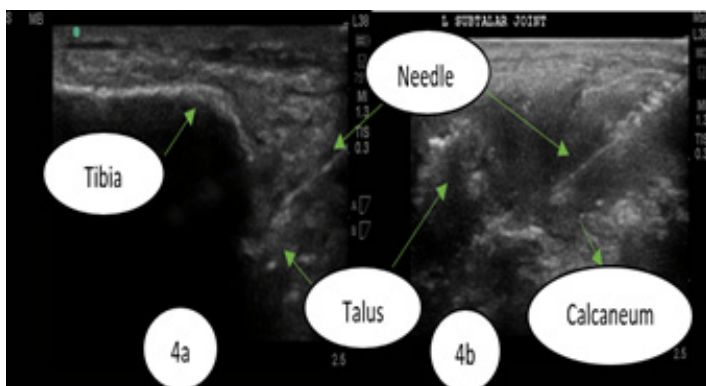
a) and b): shows ultrasound-guided needle trajectory in talar and subtalar joints.
